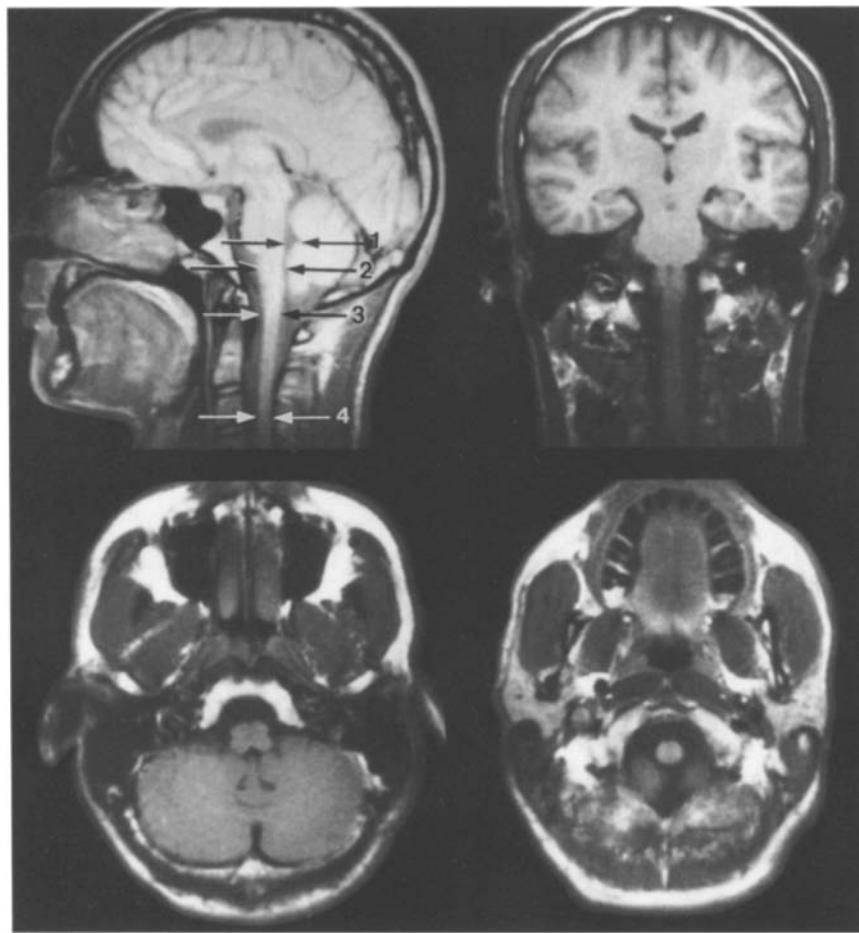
T1-weighted (TR = 400 ms, TE = 20 ms) spin-echo images of a normal subject, demonstrating the normal appearance of the brain stem and the cranial spinal cord in mid-sagittal, coronal and axial planes. The levels of measured sagittal diameters on mid-sagittal planes are marked
